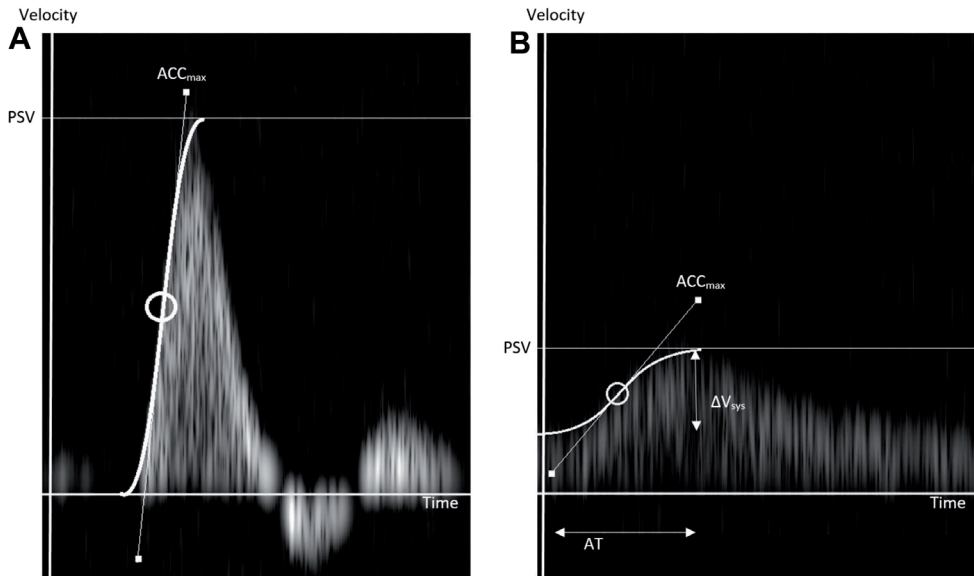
Example analysis of Doppler spectrum. A, Normal triphasic Doppler waveform. Maximal systolic acceleration ( $ACC_{max}$ ) is measured at inflection point at which upstroke changes from concave up to concave down. It is equal to slope of tangent line on curve at inflection point. B, Example of abnormal monophasic Doppler waveform.  $ACC_{max}$ , peak systolic velocity ( $PSV$ ), acceleration time ( $AT$ ), and systolic velocity gradient ( $\Delta V_{sys}$ ) are shown.  $ACC_{max}$  is measured at visually judged maximum derivative of systolic phase.  $ACC_{max}$  should not be confused with mean systolic acceleration ( $ACC_{sys}$ ), which is slope between beginning of systolic upstroke and peak of systole and is calculated using following equation:  $ACC_{sys} = \Delta V_{sys} / AT$ .
